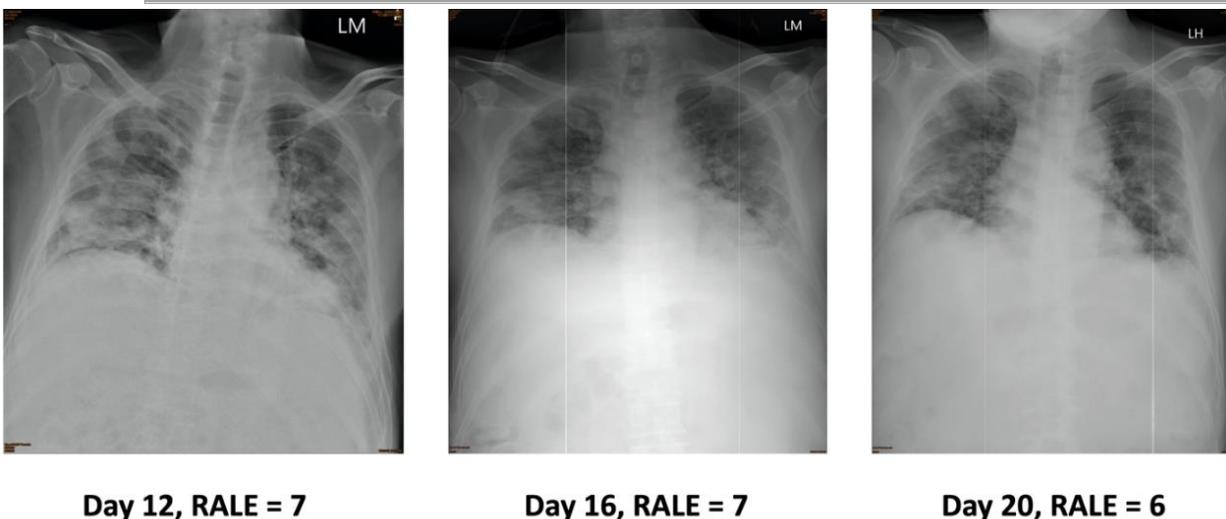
Chest X-rays of COVID-19 COVID patient 00 receiving standard medical care circa summer 2021. Radiographs show no improvement in pulmonary clearance in 20 days of hospitalization. A common term of art in chest X-rays, RALE is the acronym for “radiographic assessment of lung edema”.
